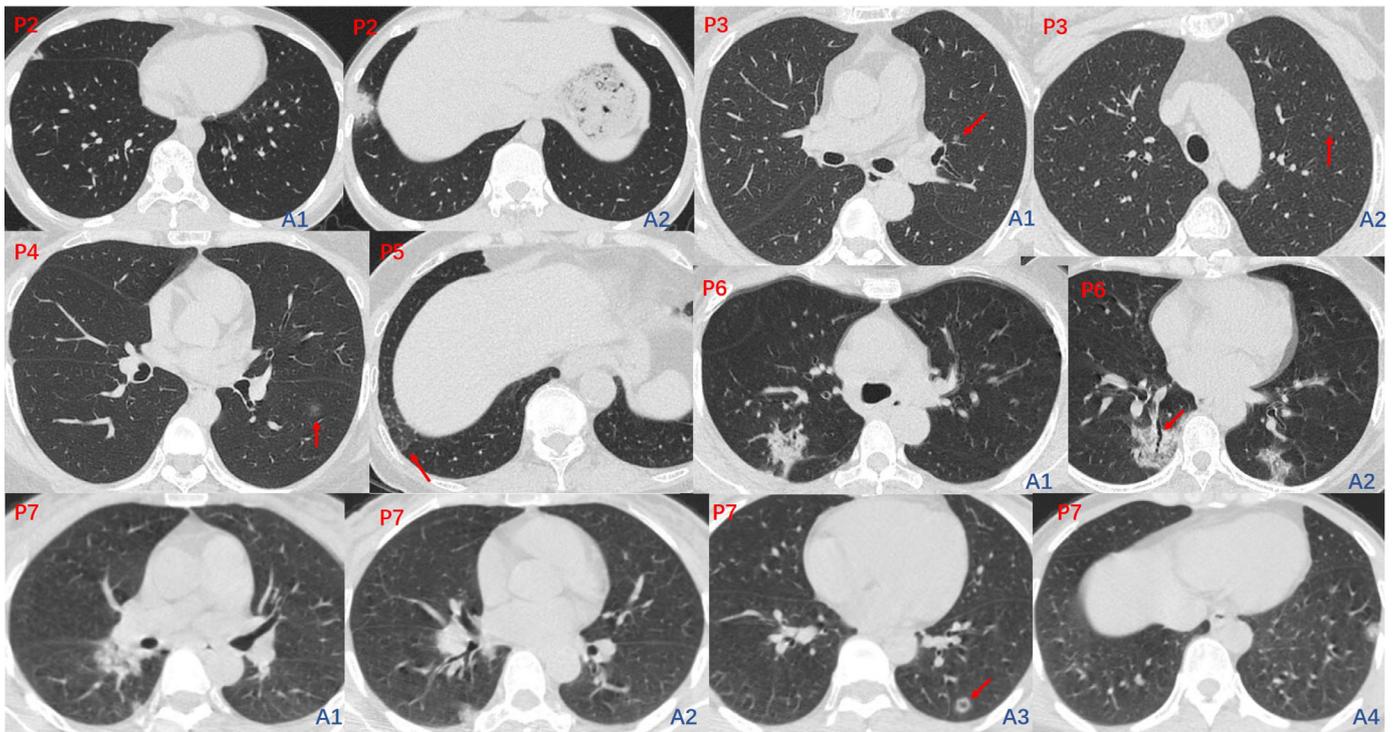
The initial CT images of P2-P7. CT images of P2 (Fig. 2, P2, A1-A2), P5 (Fig. 2, P5), P6 (Fig. 2, P6, A1-A2) and P7 (Fig. 2, P7, A1-A4) showed subpleural lesions, a nodular-like lesion with pseudocavitary sign (Fig. 2, P7, A3, arrow) and mild bronchiectasis (Fig. 2, P6, A2, arrow) were also observed within the lesion. CT images of P3 (Fig. 2, P3, A1-A2) and P4 (Fig. 2, P4) showed round nodular-like GGO lesions (P3 and P4, arrow) located in the central area of the lung.
